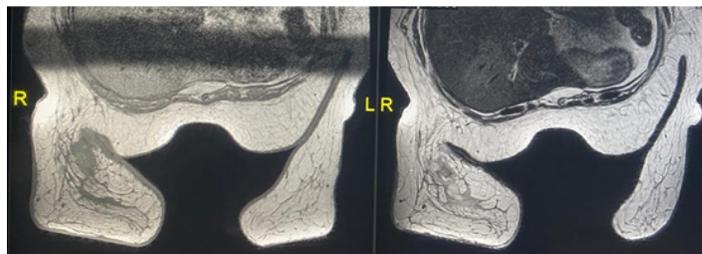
MRI-Axial T1 and T2 WI showing irregular area in the right breast posteriorly appearing fairly bright on T1 and T2 WI, following fat signal. Some areas low signal on T1 WI indicating blood products
